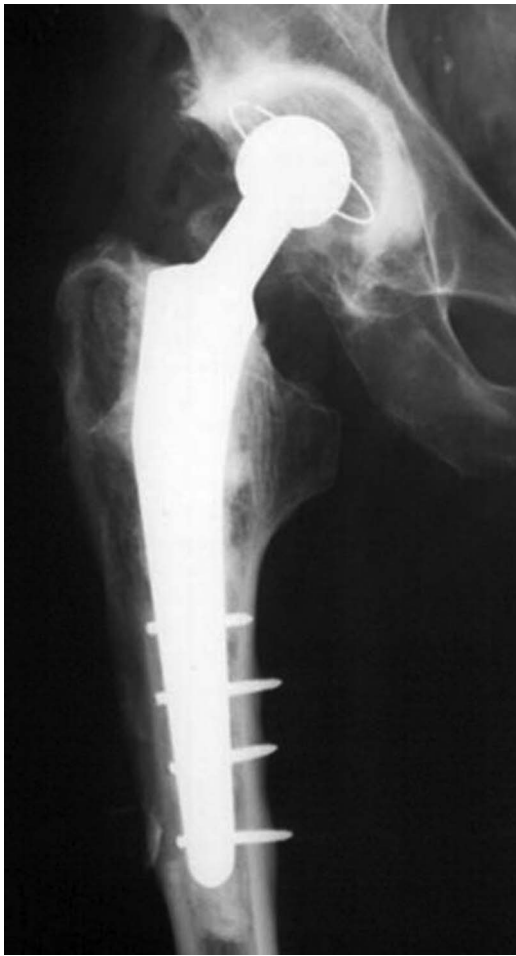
Postoperatively anteroposterior total hip arthroplasty radiograph at follow-up period of 6 months. The implant was stable with a satisfactory position, and it was possible to observe a bone remodelling process in the lateral femoral cortex.
